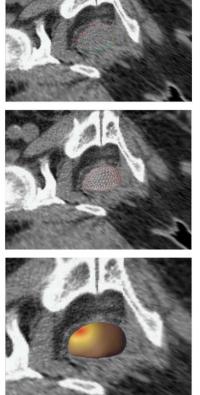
Three-dimensional (3D)-radiotherapy interactive outlining tool software process. Abbreviations: CT, computed tomography.
